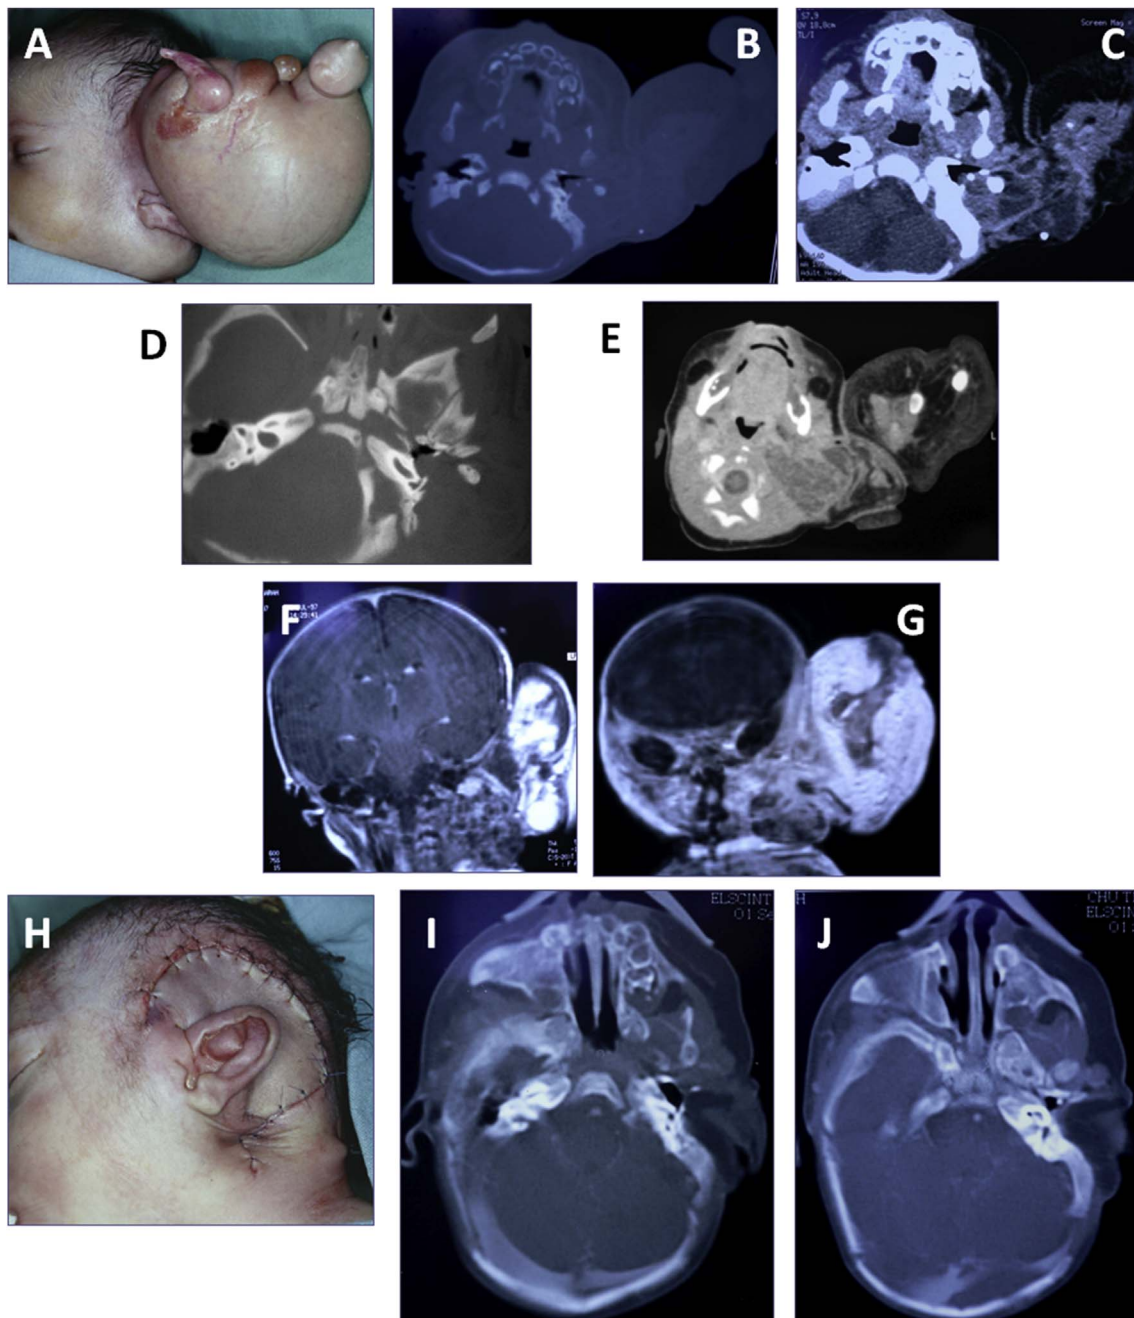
(A) Picture of the FIF before surgery. Fatty and bony mass developed inside the left petrous bone. CT axial view, bony window (B & D), and parenchymal view (C & E). Coronal views (F & G) on MRI, T1 with gadolinium. (H) Picture after surgery. Control CT, axial views, bony window (I & J).
